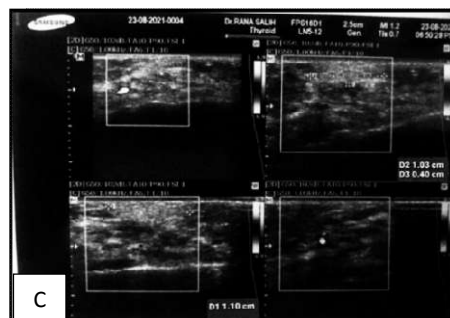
A 21-year-old female patient presented with venous malformation in the right side of the cheek, treated by bleomycin foam type (A) administration of bleomycin foam type (B) preoperative doppler ultrasonography showed the size of the lesion, (C) postoperative doppler ultrasonography showed reduction in the size.
